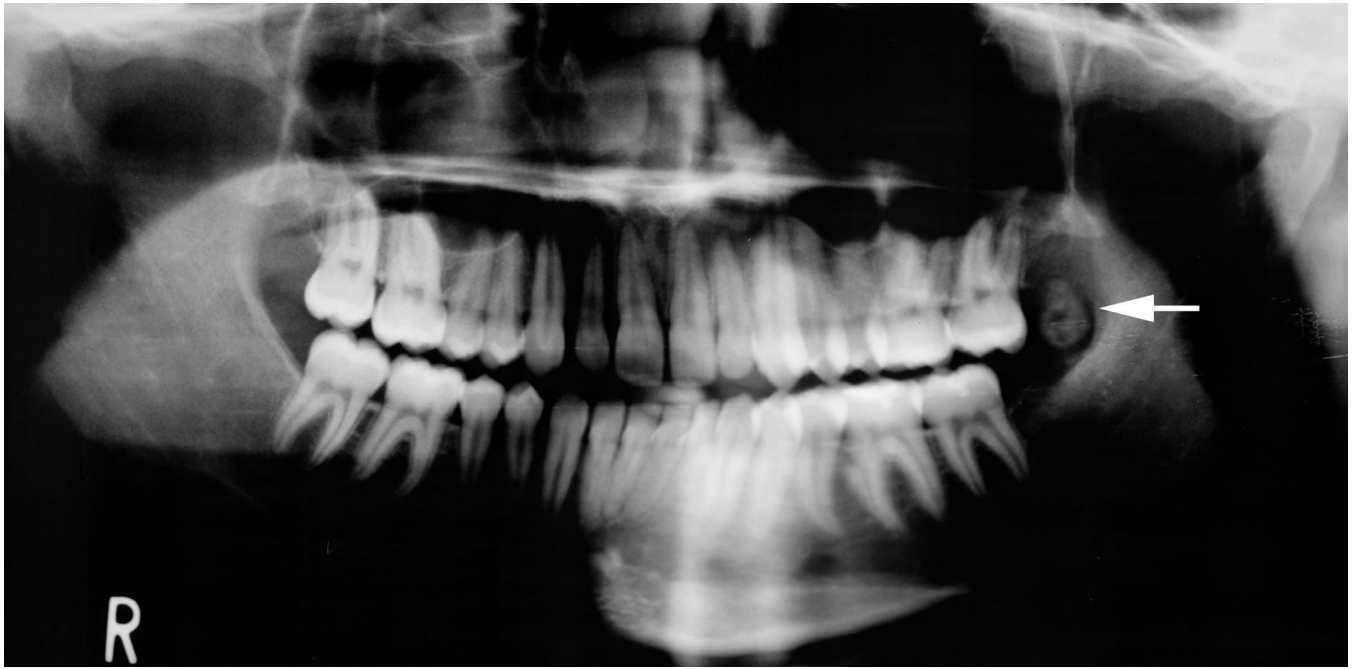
Panoramic radiograph taken at the time of initial presentation demonstrates a well defined ovoid calcified mass (arrow) just anterior to the anterior border of the left mandibular ramus. The mass reveals prominent peripheral maturation with a central area of radiolucency. Note that a radiolucent cleft separates this parosteal mass from the cortical margin of the anterior mandibular ramus.
